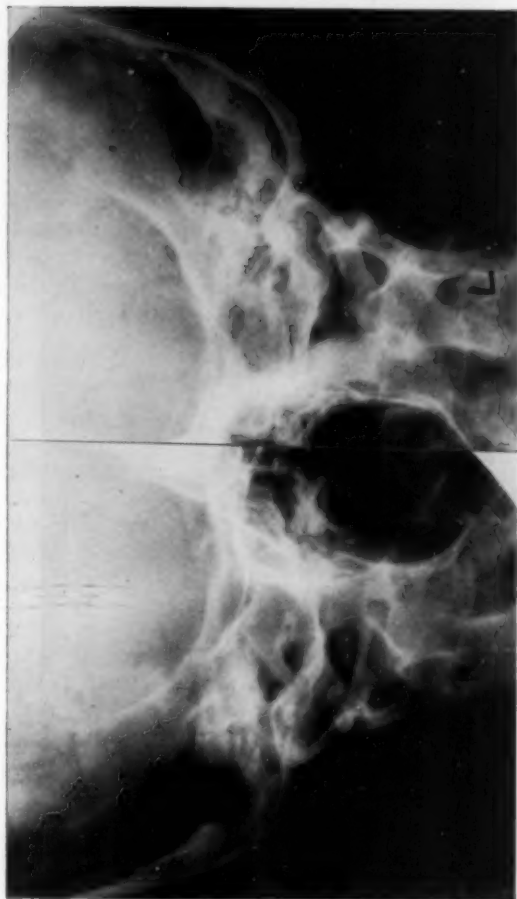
X-ray of the petrous ridge on December 18th, 3 weeks before patient's death, showed no evidence of bone destruction, although the autopsy showed almost complete destruction of this area.
